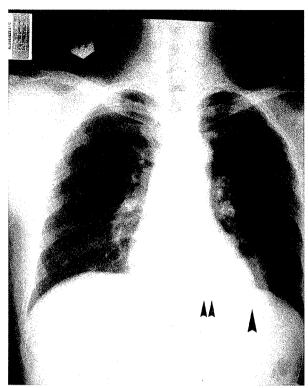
Chest X-ray, PA view, preoperative film shows two nodular densities in the lower lung. (Double arrow, large tumor, 2.5 x 3 cm in size; single arrow, small tumor, 1.2 x 1cm in size)
